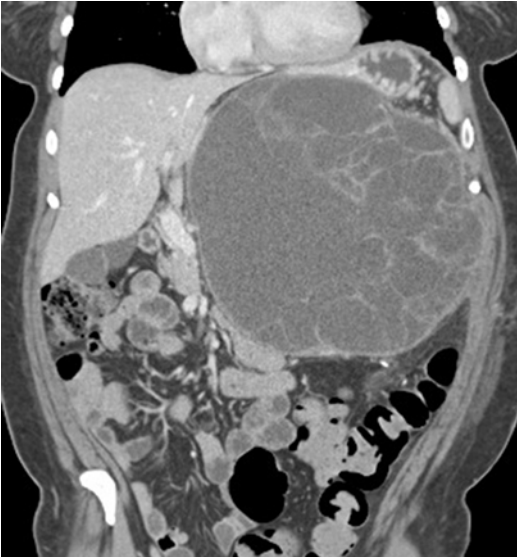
Coronal contrast-enhanced CT demonstrates a classic malignant MCN of the pancreatic tail with extensive internal septations and complexity
